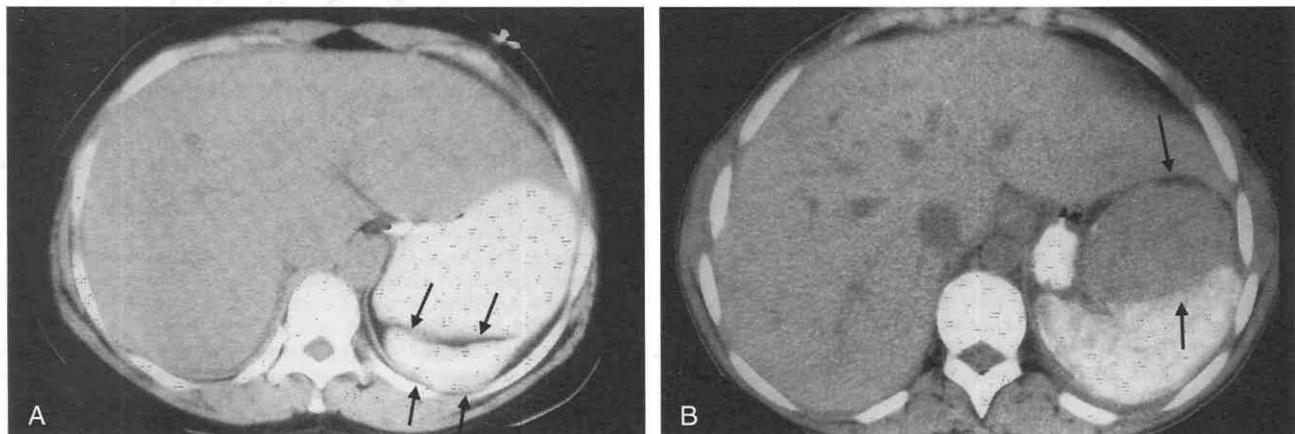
CT scans in sickle cell disease. *A*, Calcified, shrunken spleen in a patient with homozygous sickle cell anemia (*arrows*). *B*, Scan in an adult patient with homozygous sickle cell anemia and nearly complete splenic calcification, with a subcapsular hematoma (*arrows*), after undergoing exploratory laparotomy. The liver is also diffusely increased in attenuation, suggesting iron overload.
